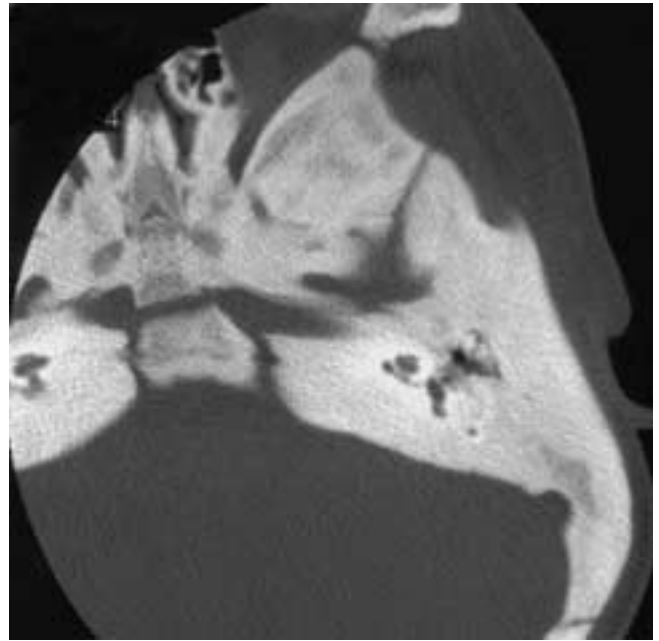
Craniometaphyseal dysplasia. Axial CT image through the left temporal bone demonstrates marked thickening and sclerotic change in the bony structure. The middle ear is significantly narrowed, with impingement on the malleus and incus. The findings were symmetric. (Courtesy of Dr. Noriko Aida, Yokohama, Japan.)
